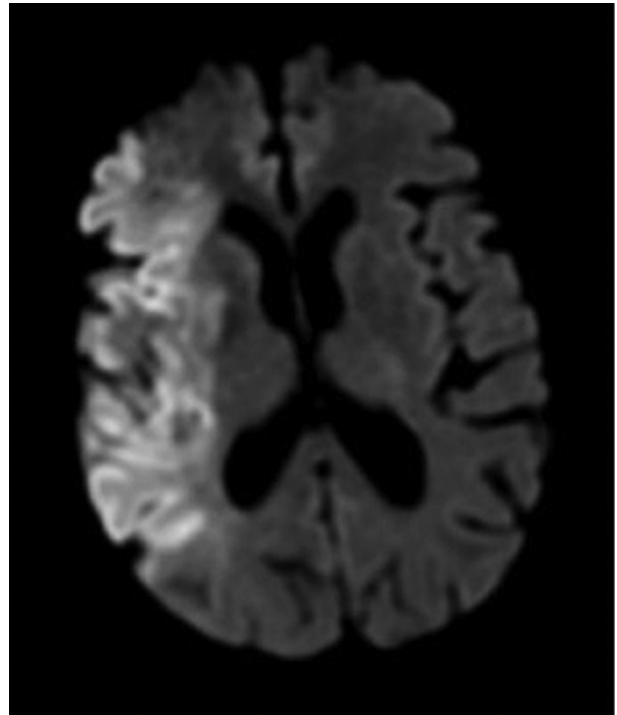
Diffusion-weighted magnetic resonance imaging in a patient with large vessel occlusion of the right middle cerebral artery and a large volume of established right hemisphere stroke. Patients such as this one are currently excluded from thrombectomy due to futility and concerns about harm, but these considerations are currently being tested in randomized clinical trials.
